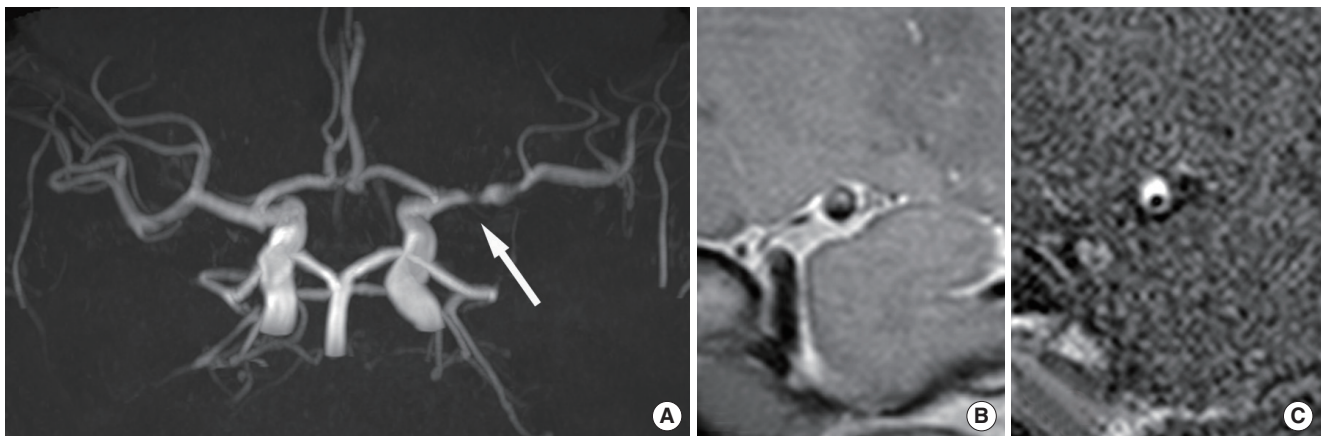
Intracranial atherosclerosis. A 58-year-old male patient presented with dizziness and three atherosclerotic risk factors. (A) Time-of-flight magnetic resonance angiograph showing severe stenosis in the left middle cerebral artery (arrow). (B) Proton-density image showing eccentric wall thickening and atherosclerotic plaques with a remodeling index of 1.04. (C) Contrast-enhanced T1-weighted image showing strong enhancement in eccentric atherosclerotic plaques.
